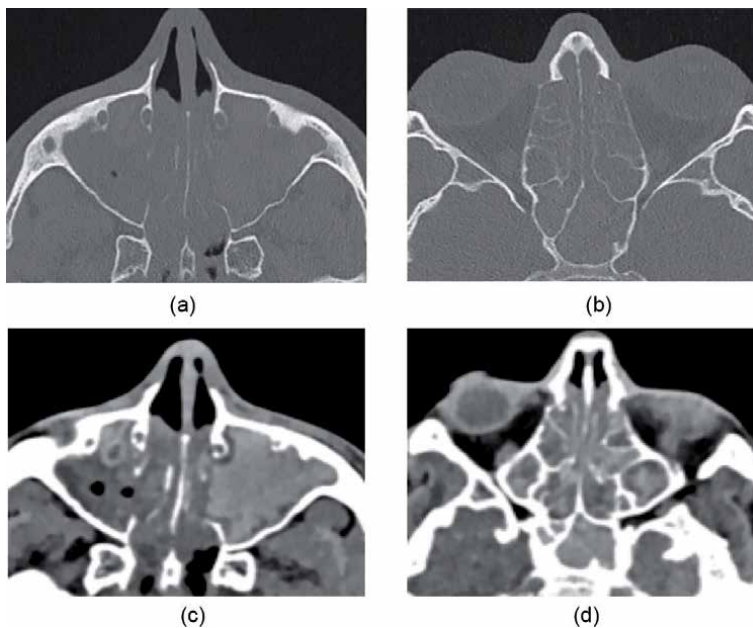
Axial CT at the level of the (a) maxillary and (b) ethmoid sinuses shows panopacification. Reconstruction, with soft tissue algorithm (c) and (d), shows high attenuation in all sinuses, which is typical for allergic fungal sinusitis. Slightly thickened, sclerotic sinus walls indicate a long-standing condition.
